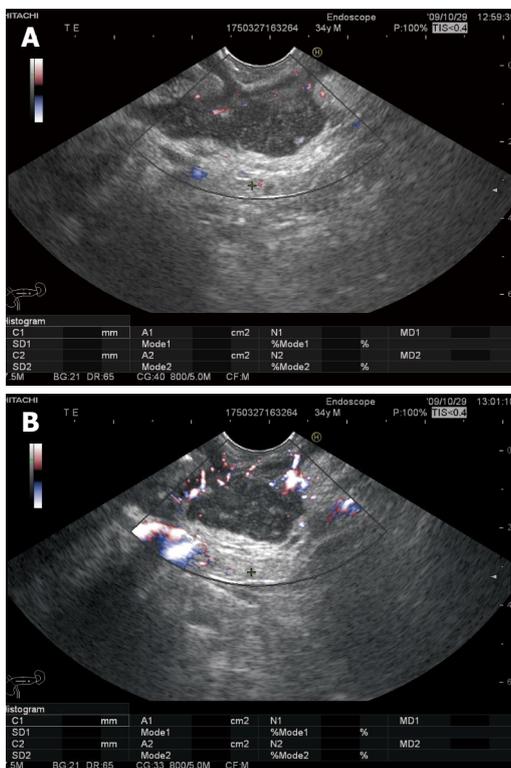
Contrast enhanced endoscopic ultrasonography of pancreatic cancer. A: Pancreatic head adenocarcinoma visualized in bidirectional non-enhanced power Doppler mode; B: Contrast-enhancement with SonoVue indicates a hypovascular mass with increased collateral circulation.
